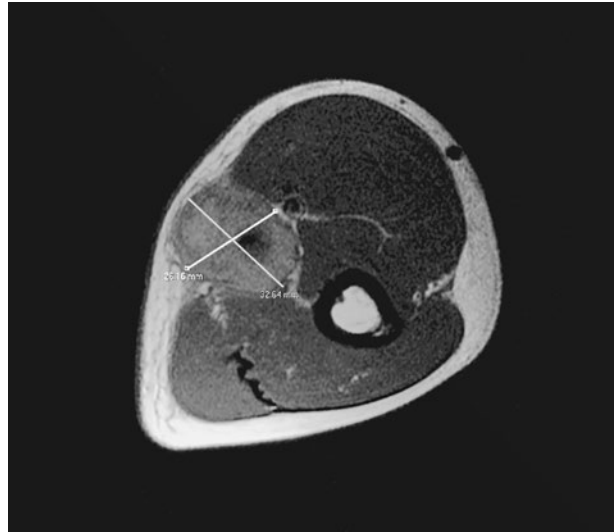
Magnetic resonance imaging. Left arm. Lesion of the medial compartment in the middle third of the left arm apparently attached to the basilic vein, with the actual tumor measuring approximately 5 × 3 cm along its different axes.
